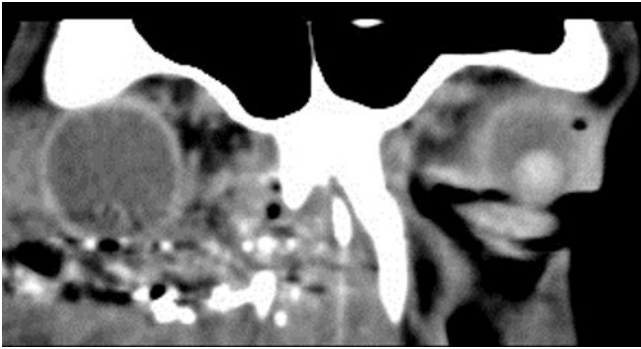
CT scan, coronal cut showing numerous gun pellets and disruption of NLD
